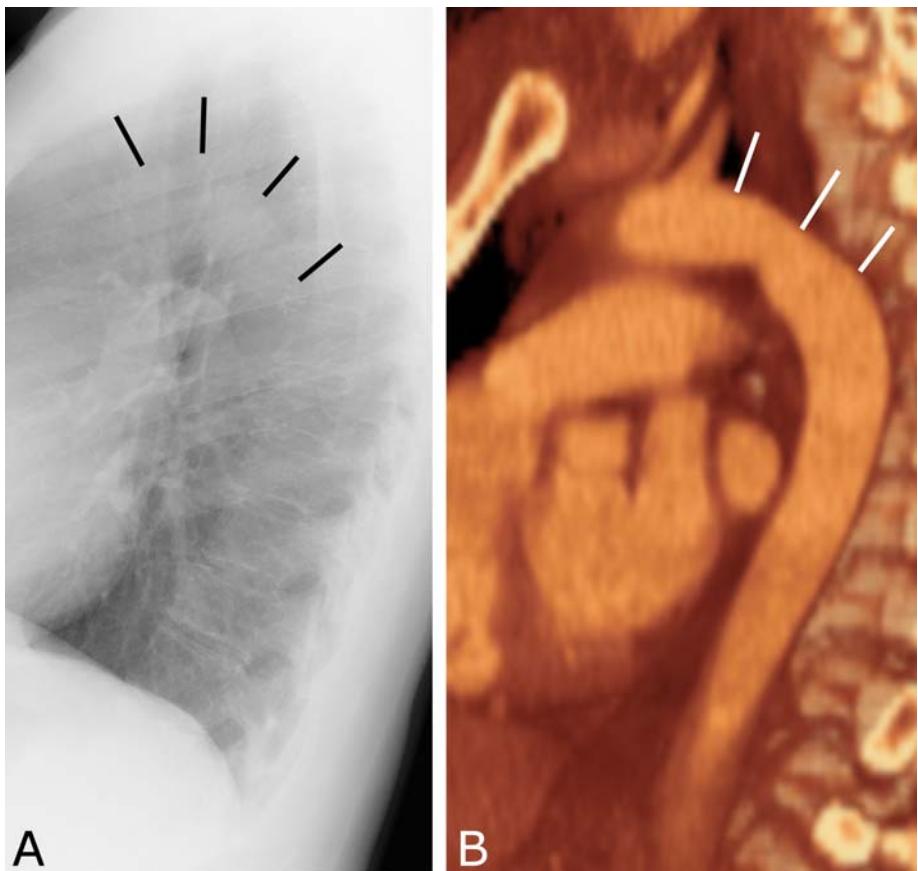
Descending aorta. A. Lateral radiograph shows the arch of the aorta continuing inferiorly as the descending aorta. Generally, the descending aorta becomes gradually less apparent when looking from superior to inferior. B. Volume rendered CT scan shows the same structure.
